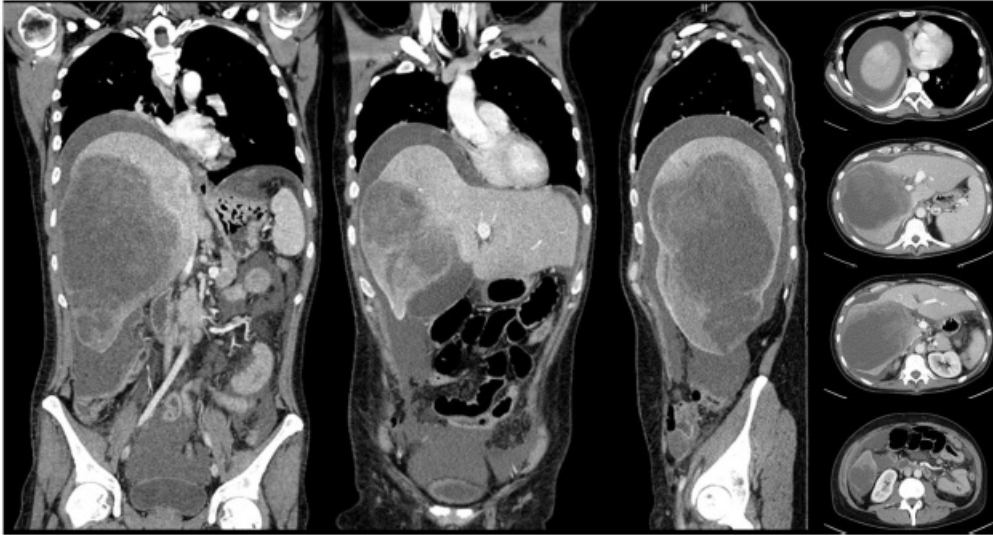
Contrast-enhanced CT showed a 23.5×14.2×14.3cm irregular iso/low mixed density lesion noted in the right hepatic lobe. The margins are not very clear. After contrast, heterogeneous mild enhancement noted on the lesion with partial cystoid density in the lesion noted without evident enhancement. There was a large amount of abdominal and pelvic effusion. The right hemidiaphragm and the diaphragmatic apex region of right hepatic lobe elevated markedly.
